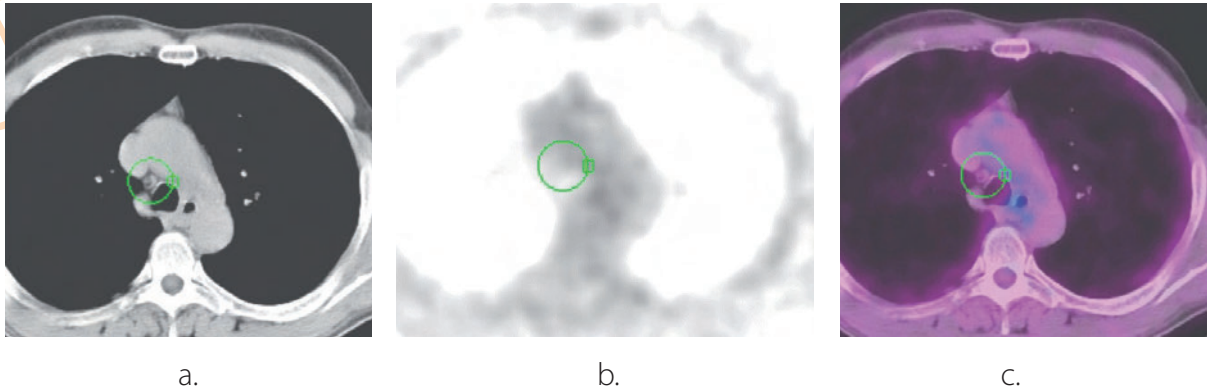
N staging: downstaging with <sup>18</sup>F-FDG. a CT of a 62-year-old man showing a pathological node in the mediastinum (green circle). b <sup>18</sup>F-FDG PET image with no uptake in the node. c <sup>18</sup>F-FDG PET/CT fused image (true negative)
